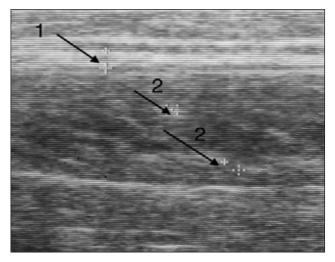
A 15-year-old patient S., diagnosis: cerebral palsy with impaired muscle tone in the form of rigidity. Sonography of the calf muscle: 1 - fascia, diameter - 1.2; 2 - fibrous tissue in the thickness of muscle fibers
